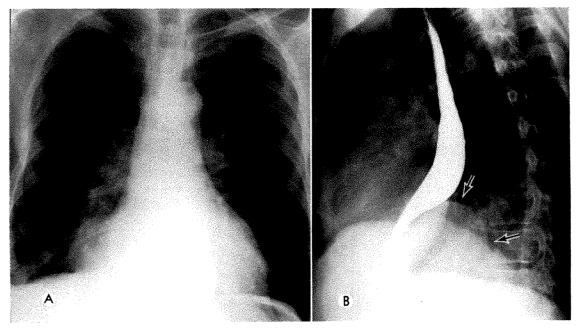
Case III. (A) Posteroanterior and (B) lateral chest roentgenograms, with barium swallow 4 weeks later demonstrate marked progression in size of the soft tissue mass in the right cardiophrenic angle and anterior deviation of the distal esophagus.
